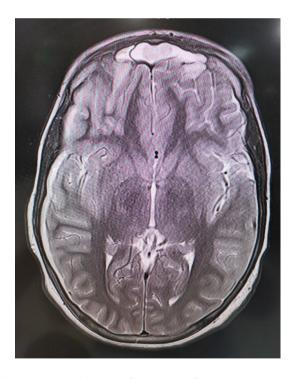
MRI brain with contrast at the next morning: Mild diffuse thickening of the pachy/leptomeninges over lying the right cerebral hemisphere with mild intervening fluid collection
